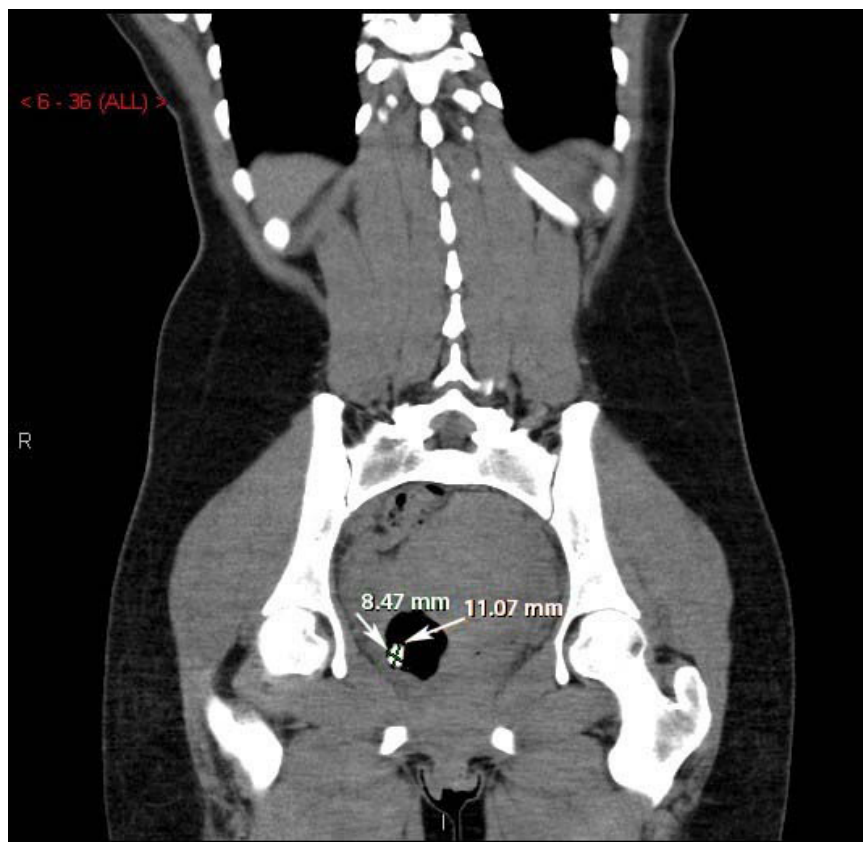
Coronal computed tomography of the abdomen/pelvis with arrows revealing a tablet-like, radiopaque mass within the cervix extending into the uterus.
